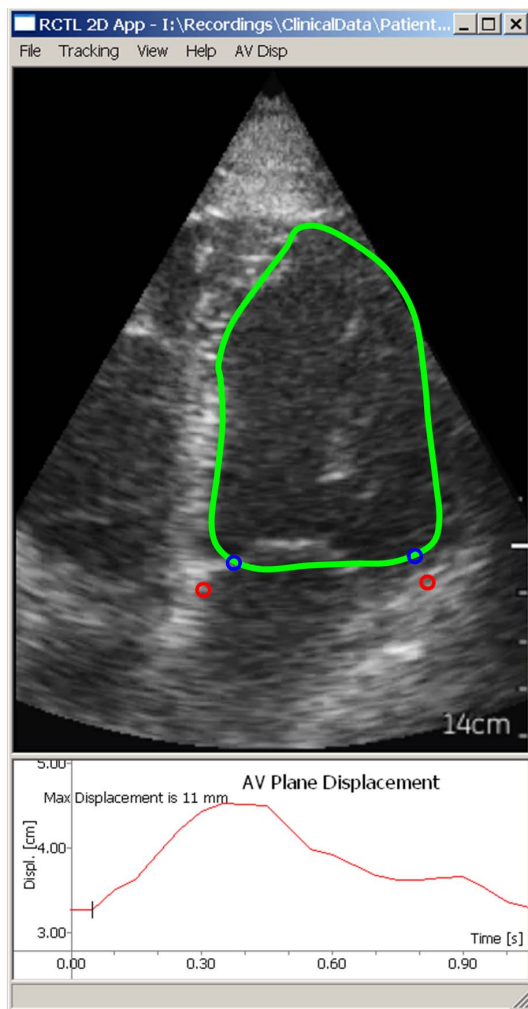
Example segmentation from a pocket-sized ultrasound recording. The circles in the basal region of the model correspond to $\mathbf{p}_{i,K}$ and the ones in the myocardium corresponds to $\mathbf{x}_{i,S}$.
